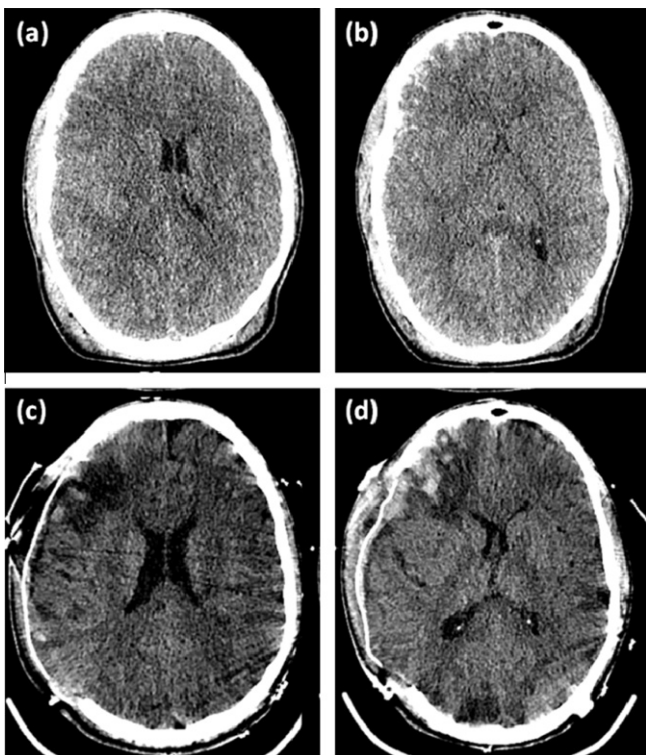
Axial CT scans obtained (a,b) before craniectomy showing injuries and (c, d) following decompressive craniectomy showing brain tissue expansion.
